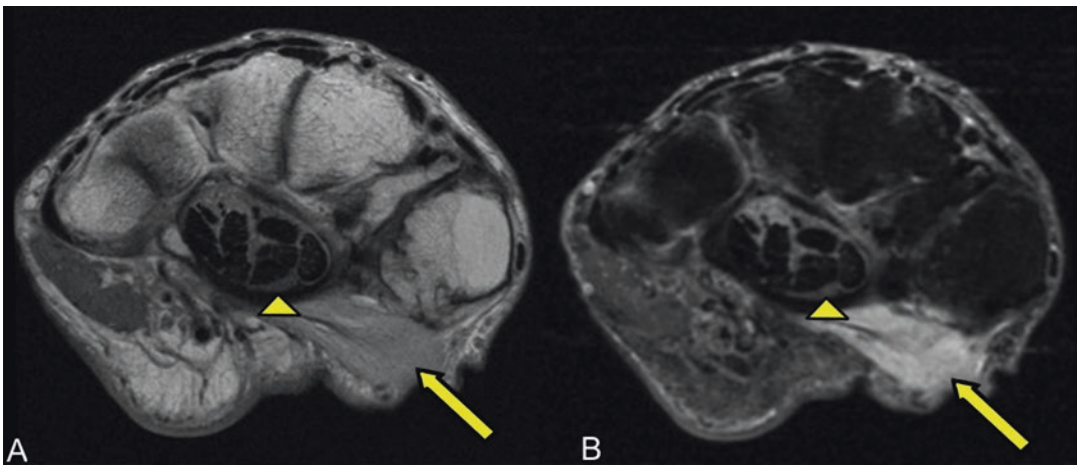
Axial MRI proton density (a) and T2 fat saturation (b)—muscle atrophy and denervation high signal within the thenar muscles (opponens pollicis and abductor pollicis brevis, yellow arrow). The median nerve is flattened within the carpal tunnel (arrowhead)
